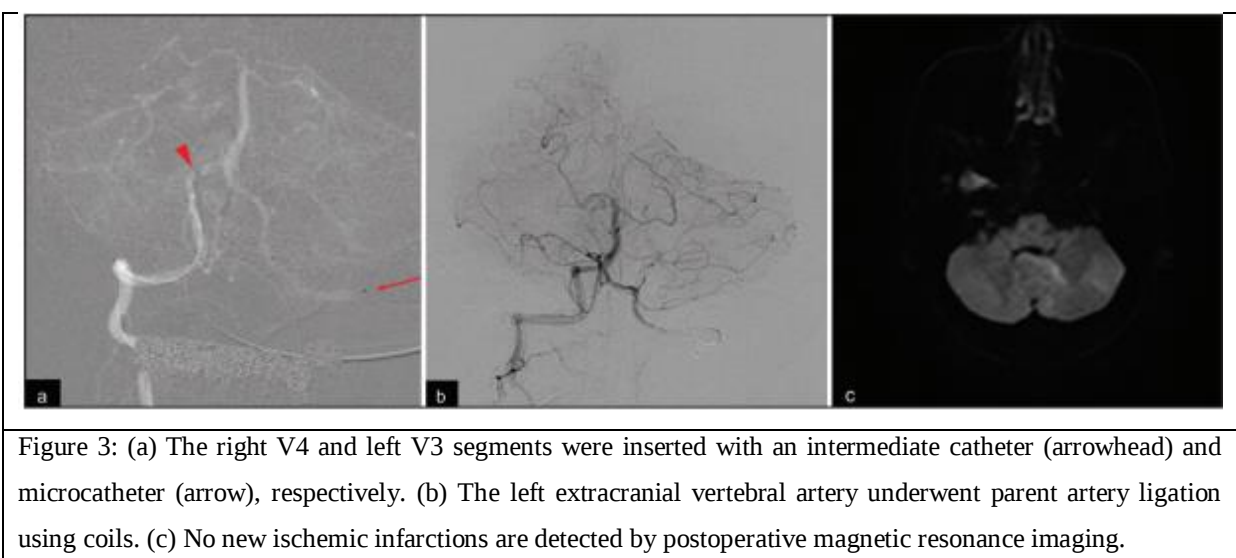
(a) The right V4 and left V3 segments were inserted with an intermediate catheter (arrowhead) and microcatheter (arrow), respectively. (b) The left extracranial vertebral artery underwent parent artery ligation using coils. (c) No new ischemic infarctions are detected by postoperative magnetic resonance imaging.
